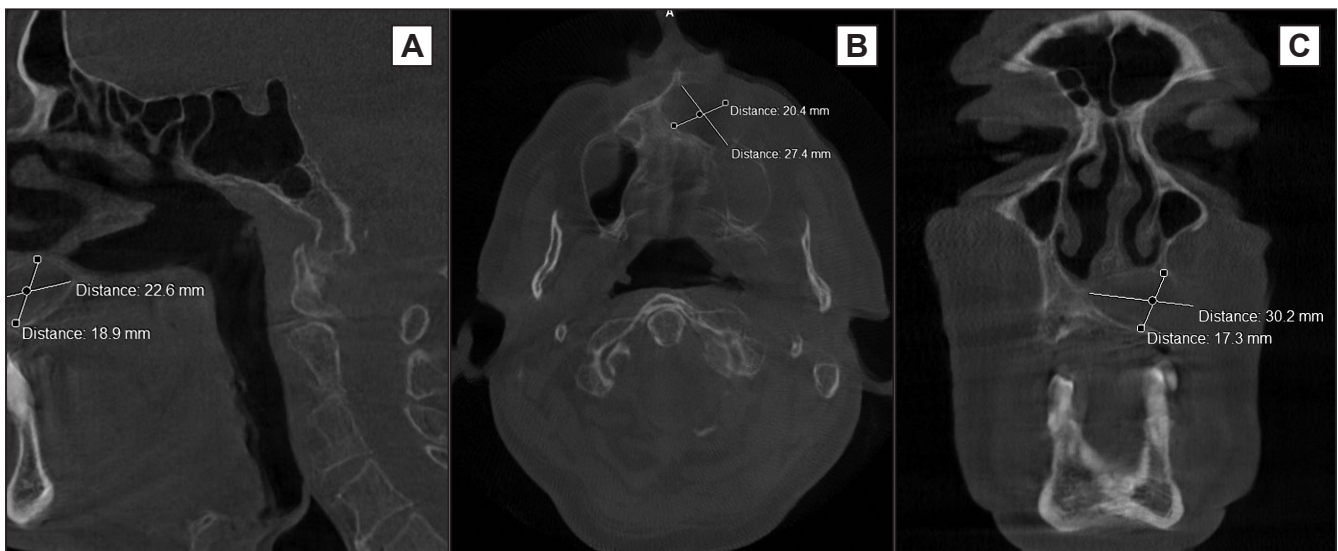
Cone-beam computer tomography scans in three projections (sagittal, axial and coronal) determining the size and location of the cystic lesion.
